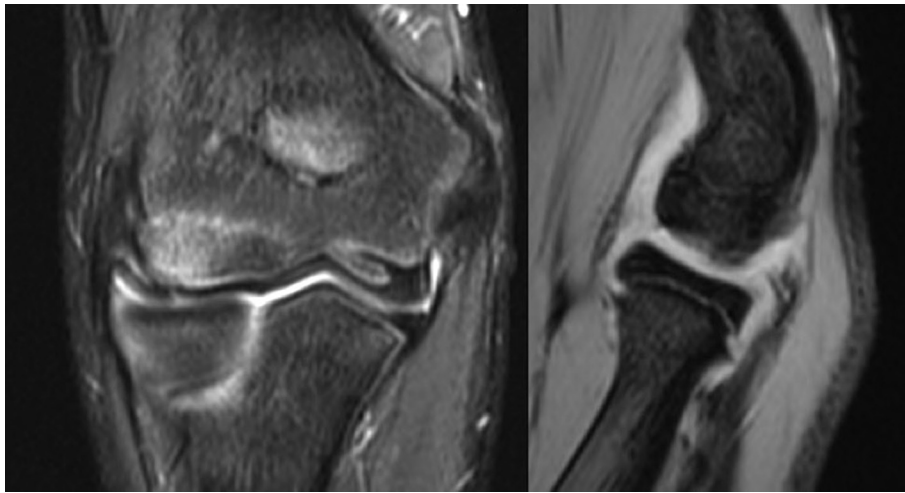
Coronal (*left*) and sagittal (*right*) magnetic resonance imaging cuts showing capitellum osteochondritis dissecans lesion.
